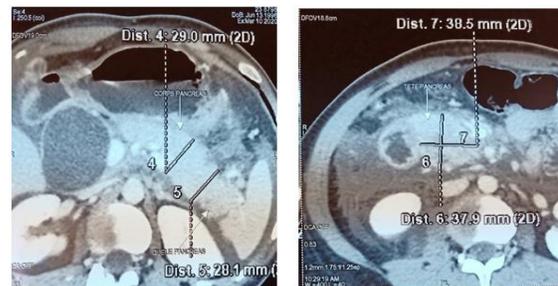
CT showing acute pancreatitis with multiple necrosis flows without signs of over-infection classified as stage E by Balthazar. CTSI = 4, Diffuse cystic dilatation of CBD suggestive of a choledochal cyst.
